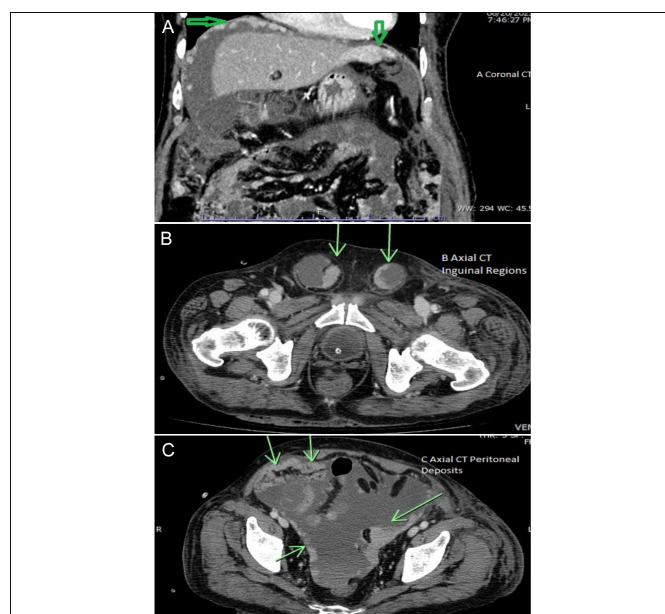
CT images of the patient. (A) Hepatic lesion. (B) Peritoneal deposits (green arrows). (C) Inguinal hernial deposits (green arrows).
